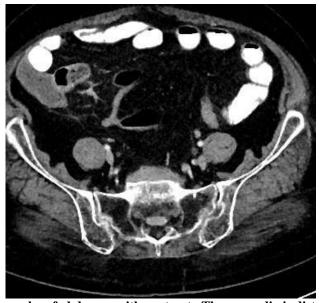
Axial computed tomography of abdomen with contrast. The appendix is distended with luminal diameter of 1.1cm & thickened enhancing wall.
